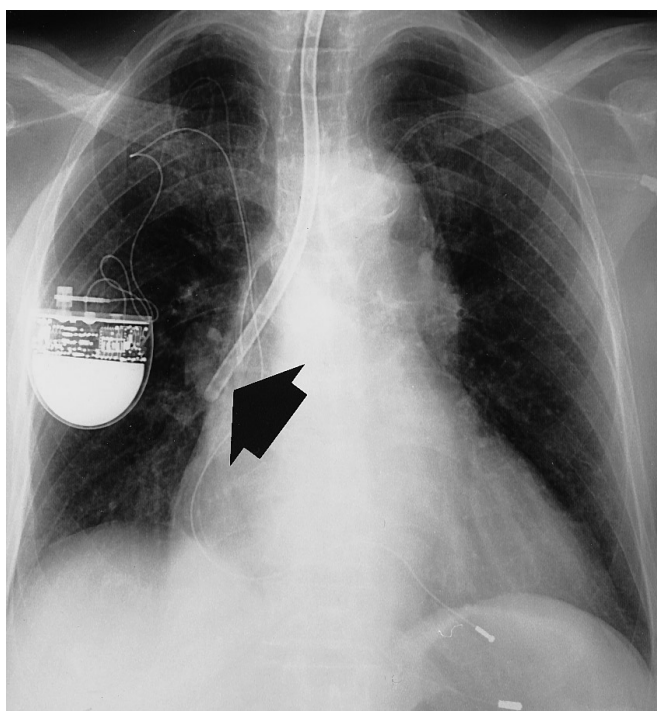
Supine chest radiograph of an 89-year-old intensive care patient shows nasogastric tube malpositioned in the tracheobronchial tree. The nasogastric tube follows the course of the trachea and abuts in the right main bronchus (arrowhead)
